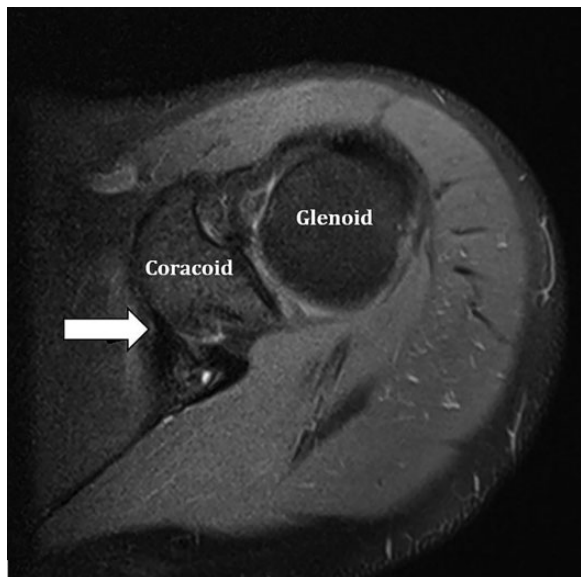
Identification of the coracoclavicular ligament on an axial T2 fat-saturated magnetic resonance imaging slice. The coracoclavicular ligament is the T2 hypointense structure (arrow) seen inserting on the medial margin of the coracoid base.
